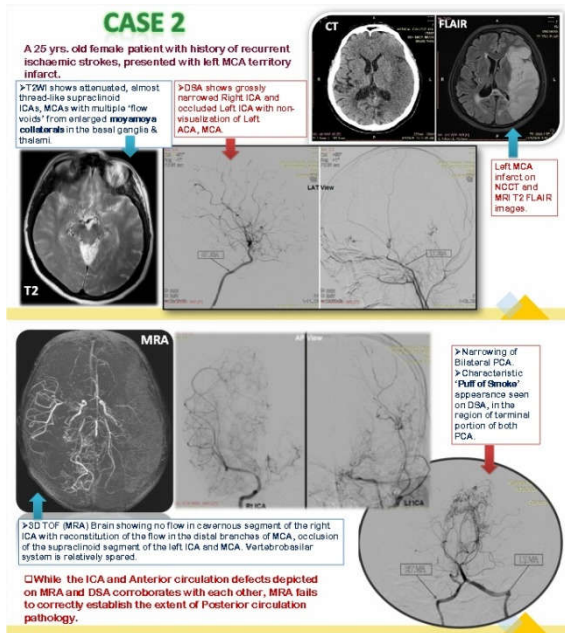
Case study showing NCCT, MRI, MRA and DSA findings in a 26 years old female diagnosed with Moyamoya disease.
